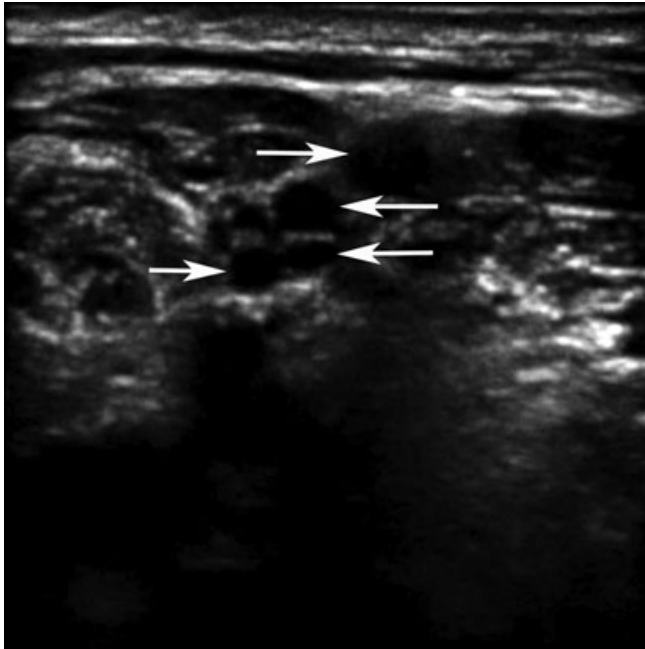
The interscalene location for the brachial plexus is shown on this US image. Arrows identify the heads of the plexus; in this case four separate nerves are seen. US = ultrasound.
